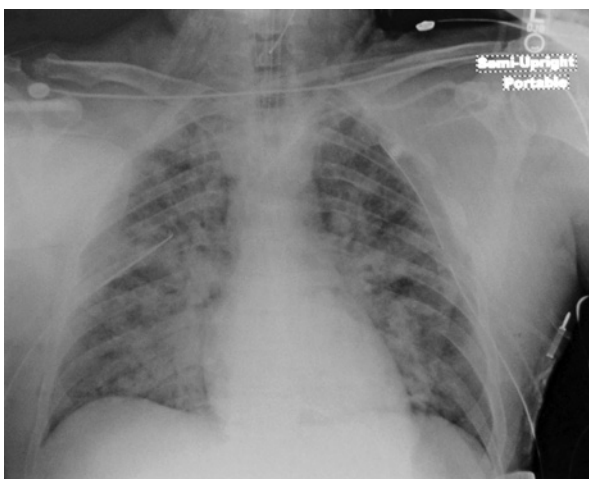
Blast lung, showing characteristic perihilar infiltrates. Computed tomography is more sensitive than plain radiography. *Courtesy of Australian Defence Force, Afghanistan, 2012.*
